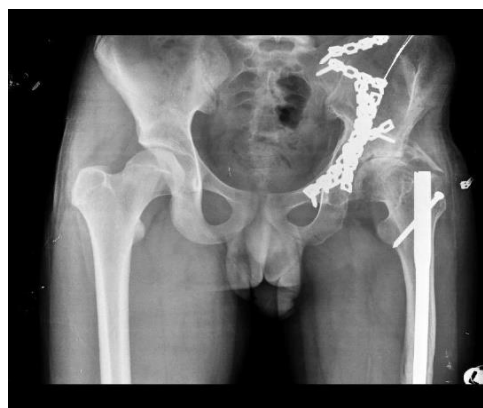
Pelvic anteroposterior (AP) radiographs 15 months after surgery
